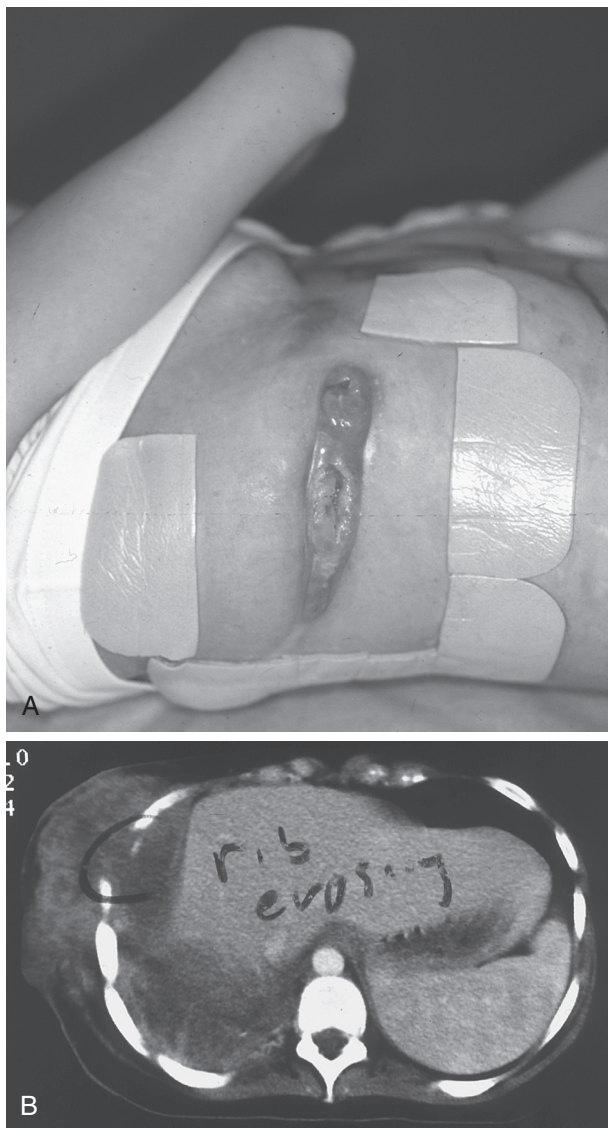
■ A, A 25-year-old woman presents to our institution with a nonhealing thoracotomy incision with a draining wound after an attempted decortication for what was initially felt to be a postpneumonic empyema. B, A CT scan demonstrates a large right lower lobe adenocarcinoma of the lung with direct invasion of the chest wall as the cause of the nonhealing wound.
